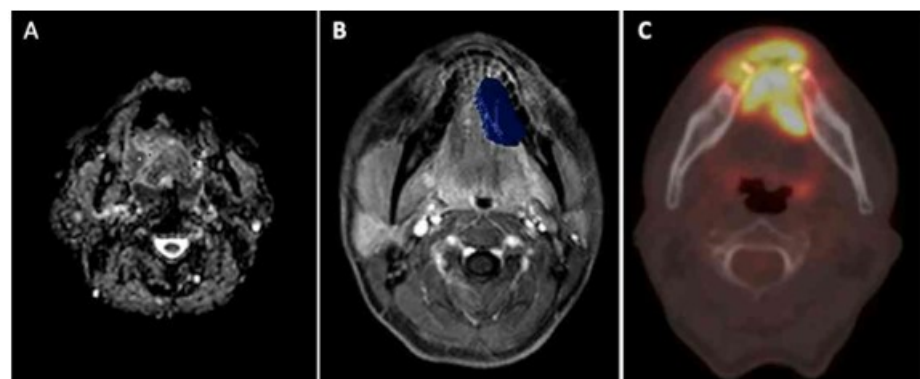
Representative image of tongue cancer on (A) DWI-MRI¹⁰, (B) DCE-MRI¹⁹, (C) PET²⁸
